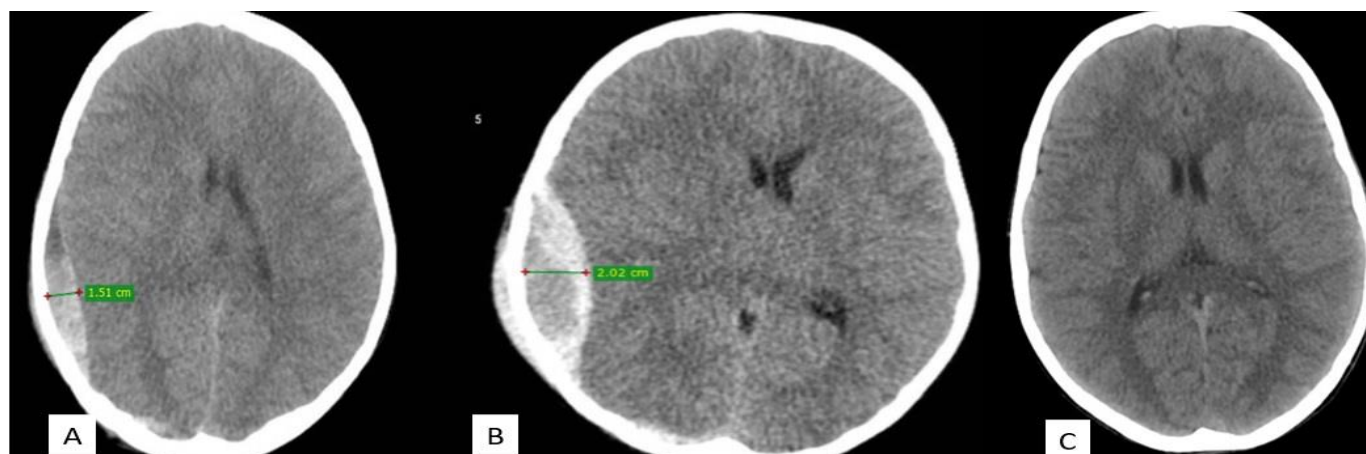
Axial CT scan of a 7-year-old male patient (Patient 5, Table 1) shows a right parietal PEDH 15 mm in thickness (A). Axial CT scan of the same patient taken 72 hours later shows a little increase (5 mm) from the earlier scan (B). Axial CT scan of the same patient taken 3 months after discharge demonstrates marked resolution of the EDH.
